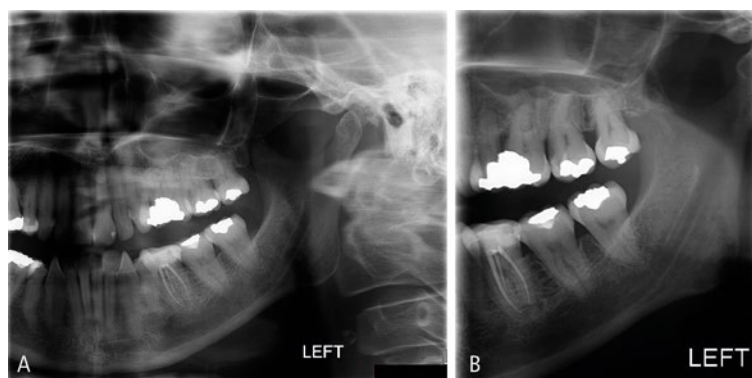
a) Sectional panoramic radiograph. b) Extraoral bitewing for the same patient showing the differing field of view and improved separation of contact points
